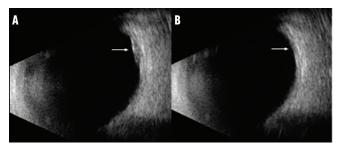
Ultrasonography showed dynamic fluctuations of the VVV in the left eye (arrows) with the lesion filling with blood up to 2.06 mm in thickness when the eye was positioned in the direction of the lesion (A) and draining down to 1.12 mm upon primary gaze (B).
